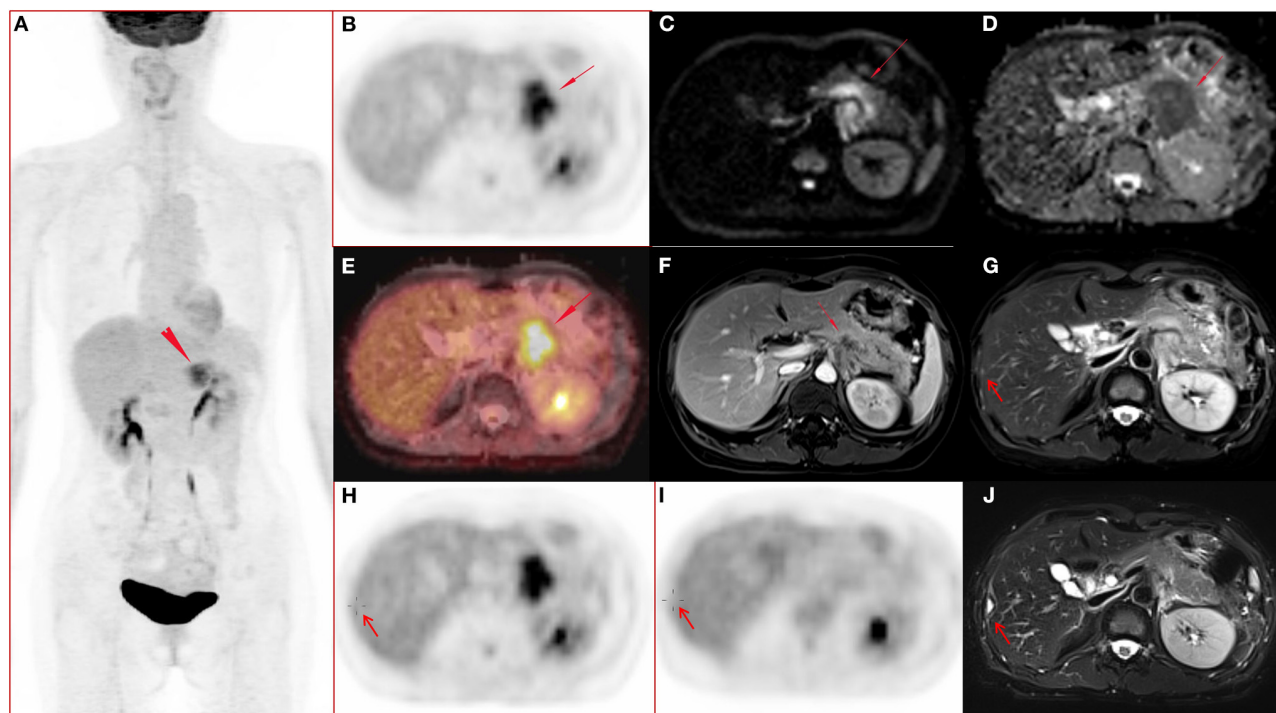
A 51-year-old female with pancreatic ductal adenocarcinoma in body and tail with hepatic metastases. (A–J) Whole body PET image with maximum intensity projection (MIP) (A) and axial abdominal PET image (B) showed FDG metabolism increased lesion in pancreatic body and tail, with SUV_{max} 7.52, SUV_{peak} 6.39, and MTV 17.43 cm^3 . Diffusion weighted imaging (DWI, $b = 800$) (C) and apparent diffusion coefficient (ADC) map (D) showed a diffusion restricted lesion in pancreatic body and tail. (E) Fused image of PET and ADC showed a diffusion restricted lesion with hyper FDG metabolism. (F) Contrast enhanced (CE) T1 weighted image (T1WI) with fat suppression (fs) on late arterial phase showed hypo-vascular lesion and dilated main pancreatic duct, and the maximum diameter of the lesion was 4.7 cm. (G,H) Metastasis in the right lobe of the liver (arrow) confirmed by surgery operation (2 days after the initial PET/MR examination) and histo-pathological examination, and the lesion showed slightly hyper-intensity on T2 weighted image with fat saturation (G), no FDG avid lesion on PET image (H). (I–J) Follow up PET/MR 112 days after operation showed the operated region with hyper-intensity in T2 weighted image with fat saturation (J) and without abnormal FDG uptake on PET image (I).
